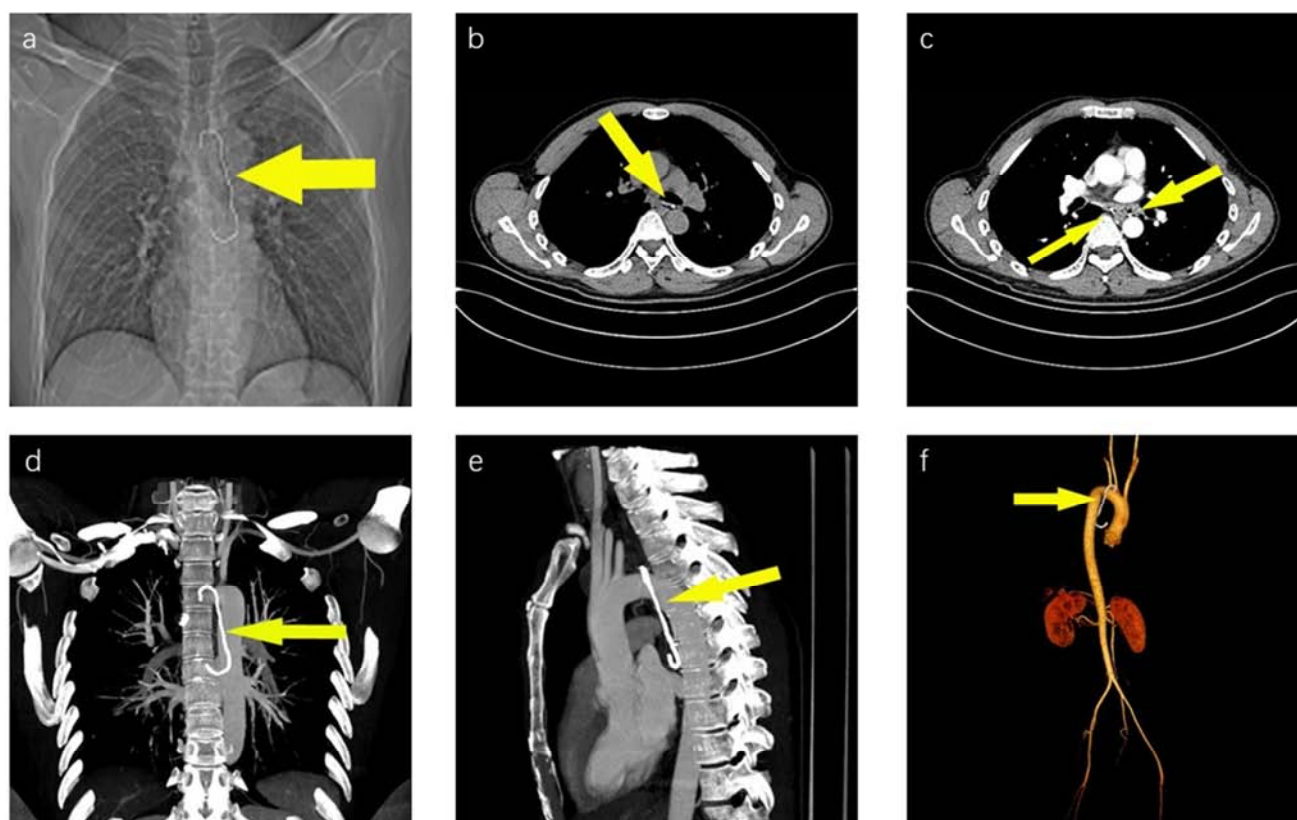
Computed tomography: a coronal fluoroscopy showed a metal wire incarcerated in esophagus (yellow arrow); b the metal wire was almost insert into the aorta (yellow arrow); c enhanced CT showed no contrast extravasation from the aorta (yellow arrow); d coronal CT angiography showed spatial position from the metal wire to aorta (yellow arrow); e sagittal CT angiography showed spatial position from the metal wire to aorta (yellow arrow); f 3D-CTA reconstruction of blood vessels showed spatial position from the metal wire to aorta (yellow arrow).
